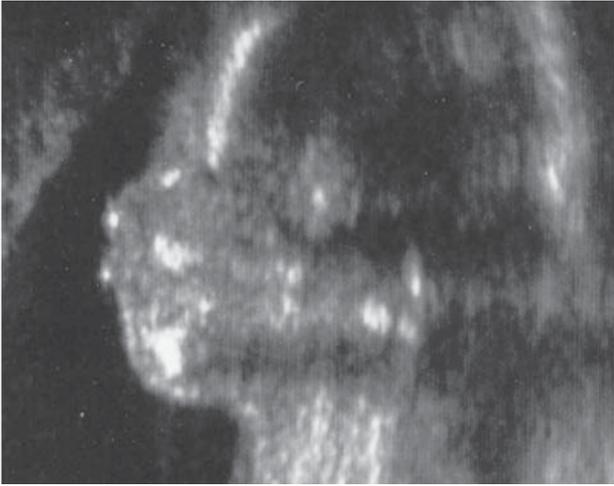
Hypoplastic nasal bone is seen in a mid-sagittal profile view of a fetus of a 19 y.o. woman with increased serum screen risk for Down syndrome. The only other sonographic marker finding was a left ventricular echogenic intracardiac focus. Amniocentesis confirmed Down syndrome
